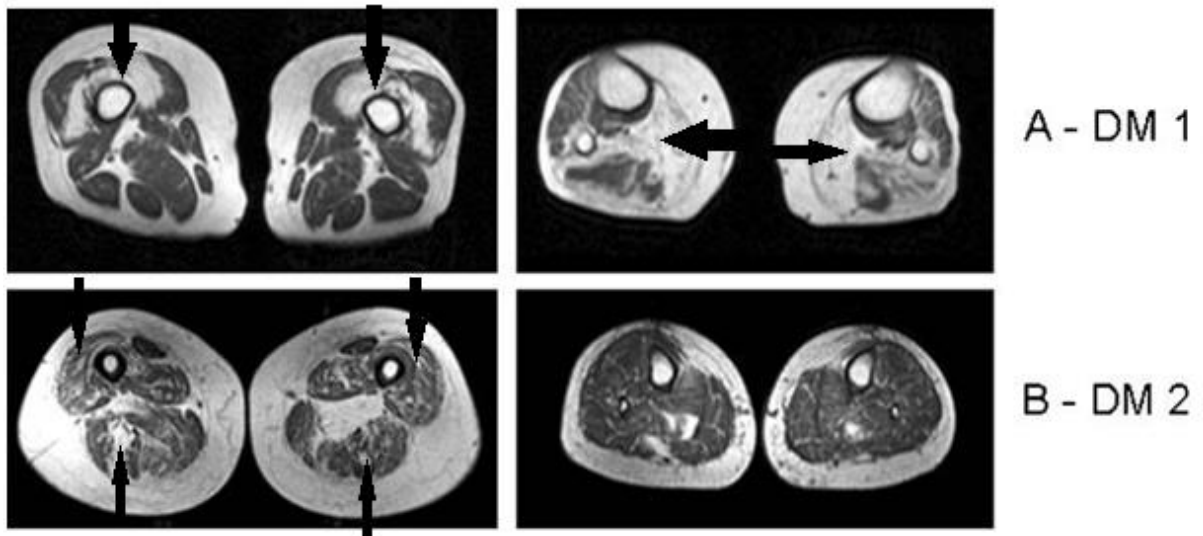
Muscle MRI of lower extremities [281]. (A) MD1 is typically characterized by distal more than proximal muscle involvement showing predominant affliction of the soleus, medial gastrocnemius, and proximally the anterior thigh compartment with relative sparing of the rectus femoris. (B) MD2 shows more involvement of the proximal muscles with the affliction of the quadriceps and sparing of the rectus femoris and gracilis muscles. Arrows show predominant affliction.
